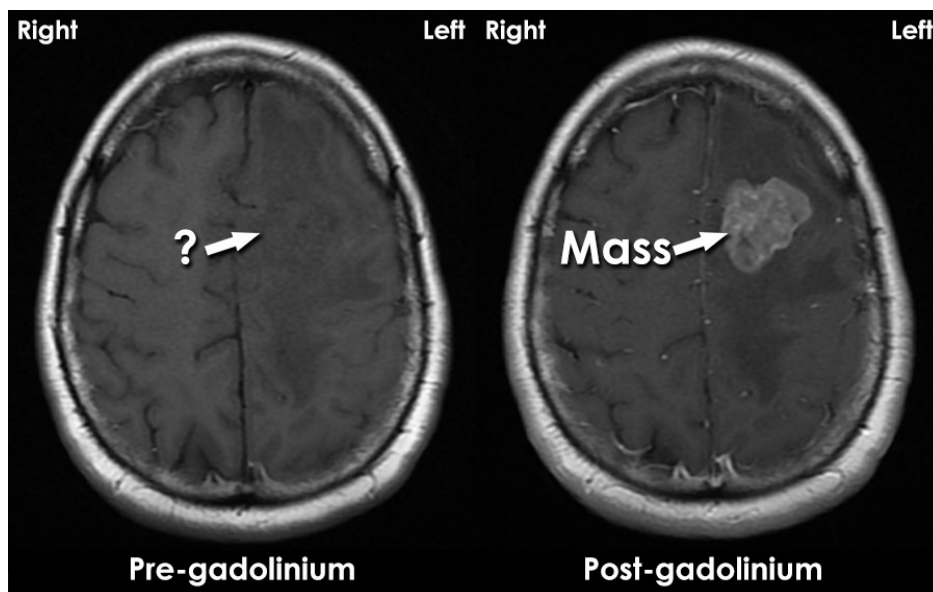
Projection of Gadolinium contrast in CT Scans.
